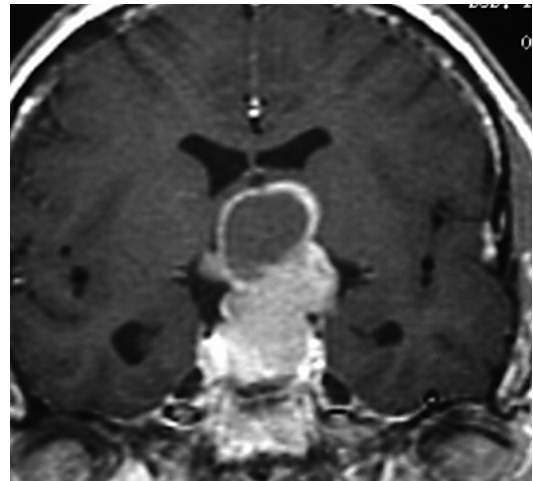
The MR image shows the cystic and solid parts of a craniopharyngioma. The coronal MR image of a tumor compressing the visual pathway shows the obliteration of the 3rd ventricle (preoperative image)
